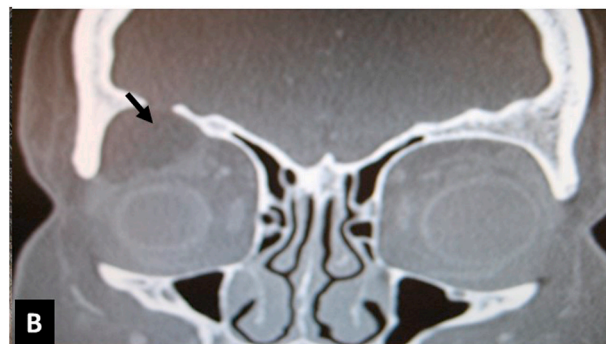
Coronal CT scan in case 1 with large orbital cystic lesion in the right superior orbit extending into the frontal sinus through a bony defect in the orbital roof. The lesion is marked with black arrow.
